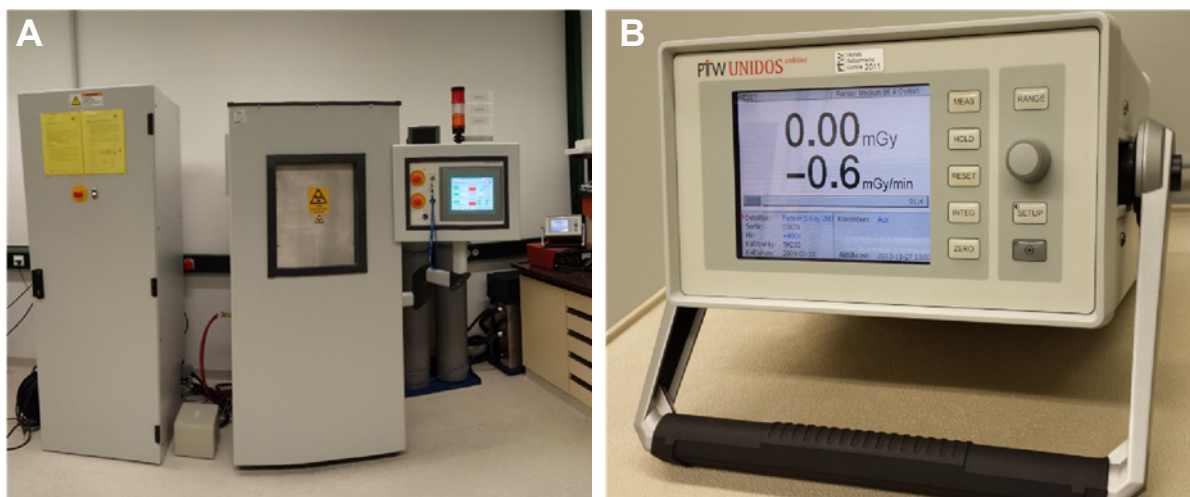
X-ray facility and dosimeter: (A) X-Strahl RS 225 X-Ray Facility at DLR comprising of a generator, an exposure cabinet (lead door closed) and a control panel (from left to right) and (B) Front side of the UNIDOS^{webl ine} dosimeter showing the operation panel. The ionization chamber of the dosimeter is placed within the exposure cabinet of the X-ray irradiator.
